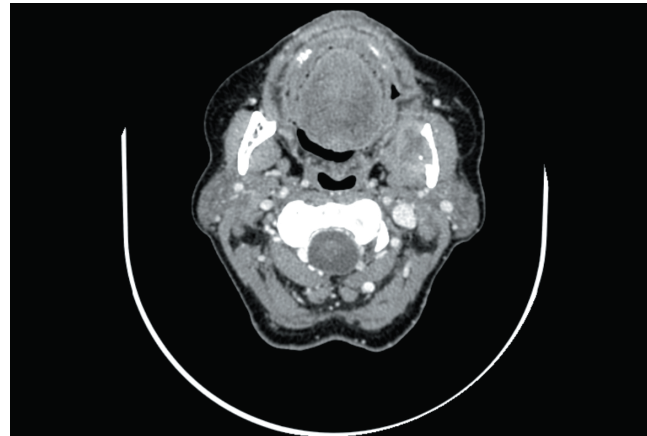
CT axial image from the mandibular metastasis at the time of the biopsy.
